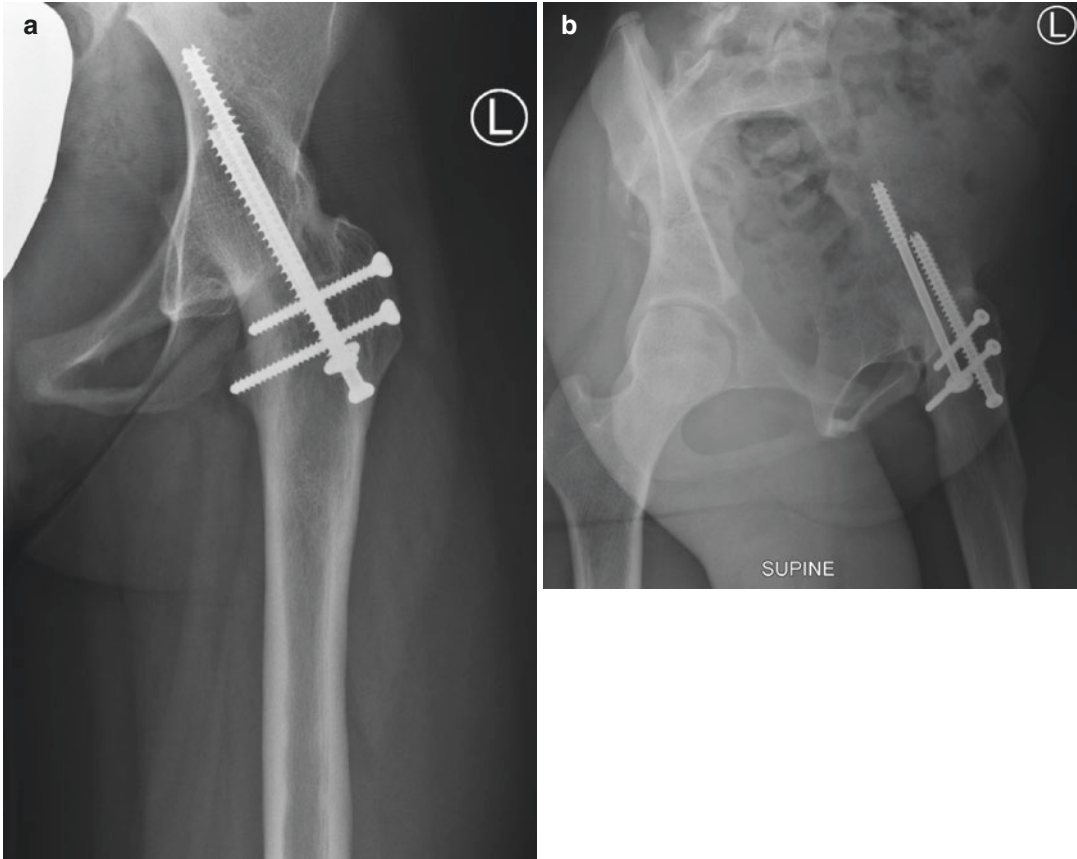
Left hip anteroposterior (a) and lateral (b) radiographs showing a solid fusion of the hip and remodelling of the femoral osteotomy site at 2 years postoperative. (c) Standing anteroposterior full length lower
